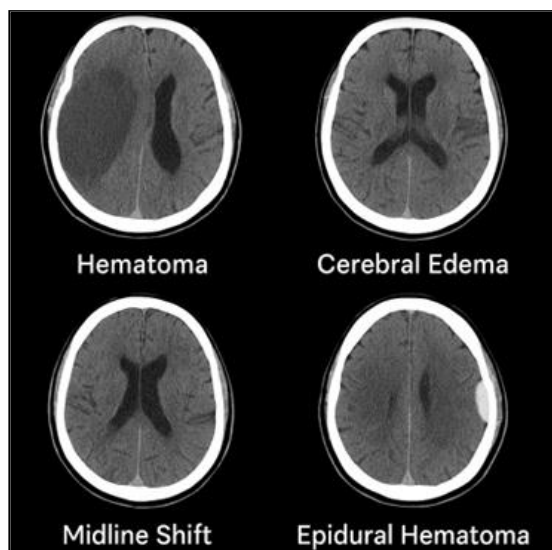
CT images of Hematoma and Cerebral Edema
